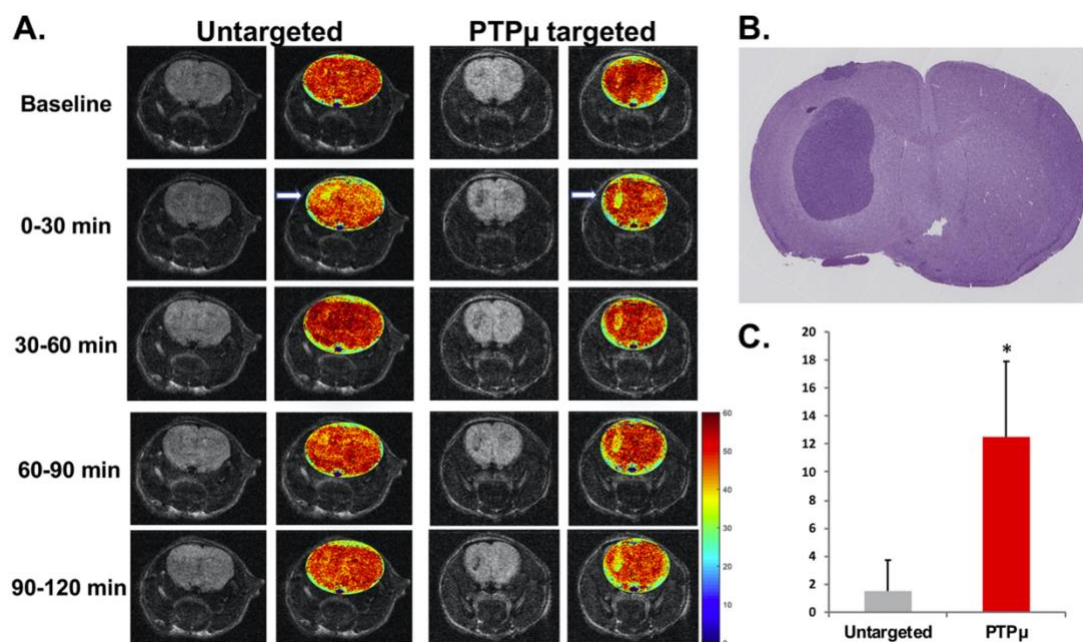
The PTP μ -targeted nanochain shows in vivo binding to U-87 MG intracranial tumors and T2-weighted contrast enhancement.
